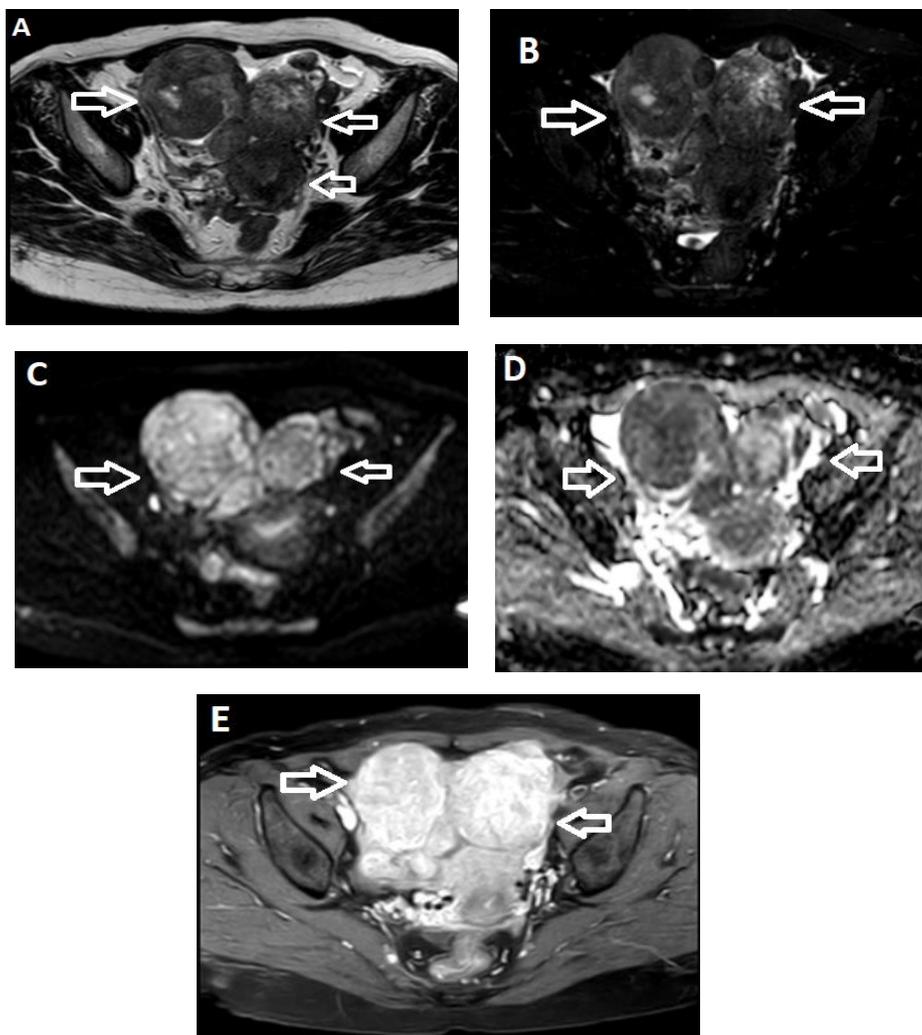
(A) Axial T2-weighted sequence showed bilateral ovarian solid masses (arrowed) with heterogeneous SI, ascites and LN enlargement. (B) Axial fat suppression T2 WI showed no fat suppression within ovarian masses (arrowed). (C) DWI & (D) ADC maps showed bilateral ovarian masses with true restricted diffusion (arrowed). (E) Contrast-enhanced axial T1WI showed intense heterogeneous enhancement of masses (arrowed) more than that of myometrium. O-RADS MRI score was 5 and Non-Contrast MRI was 5.
